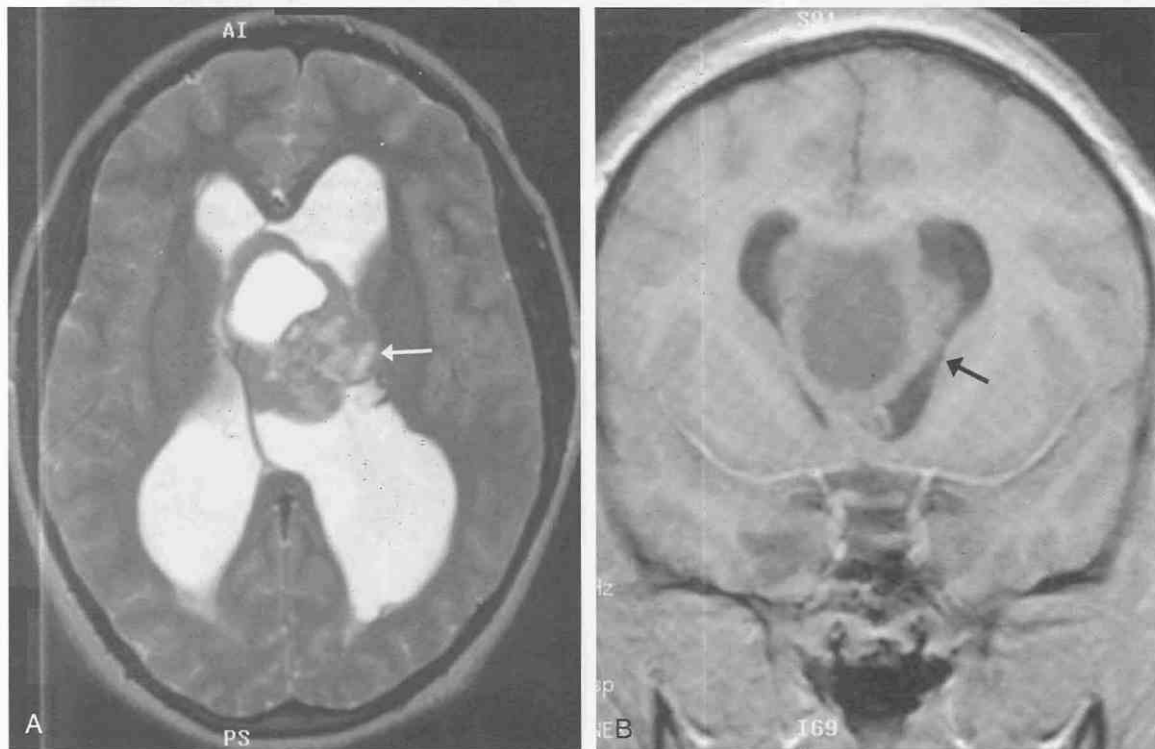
Central neurocytoma in the anterior body and frontal horn of the left lateral ventricle. A, Axial T2-weighted MR image demonstrates a large multilobulated heterogeneous but predominantly isointense (with gray matter) intraventricular mass arising from the lateral wall of the left lateral ventricle (arrow) with multiple small hyperintense foci and one large intratumoral hyperintense cyst. The tumor expands the left lateral ventricle. Enlargement of both lateral ventricles is likely secondary to obstruction of the foramen of Monro by this mass. B, Coronal T1-weighted spoiled gradient echo image following intravenous gadolinium: the plane of section passes through the anterior portion of the tumor. The more solid portion of this tumor demonstrates faint contrast enhancement. Note the extension of the tumor inferiorly and medially at a level just anterior to the foramen of Monro.
